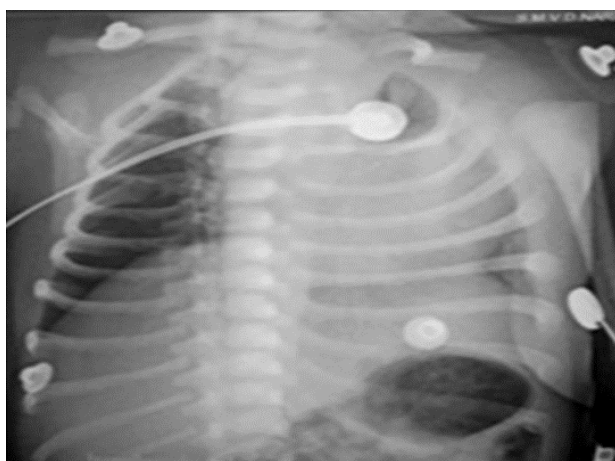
Chest x-ray showing oligemic right lung, elevated hemidiaphragm, hyperinflated and hyperlucent left lung.
